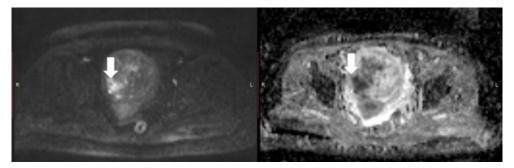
DWI (*b*-value 1000s / mm²) reveals high SI with corresponding hypo SI at the ADC map (arrow). This change is due to the presence of blood as identified in the T1 sequence with fat saturation.
